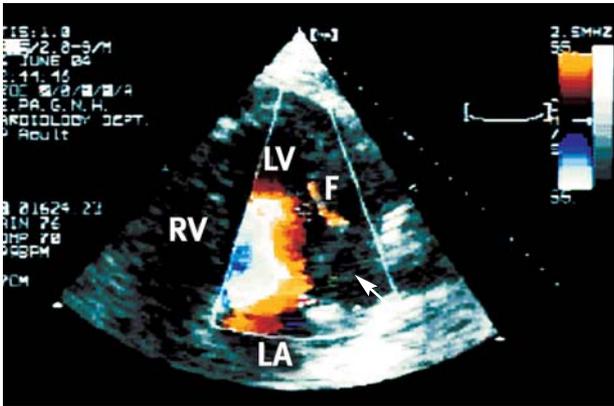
Four-chamber view from Case 1, showing a mass (arrow) which invades the free lateral wall of the left ventricle while pericardial fluid around the apex is evident. The colour Doppler reveals the presence of blood flow within the mass. LV – left ventricle; RV – right ventricle; F – blood flow.
